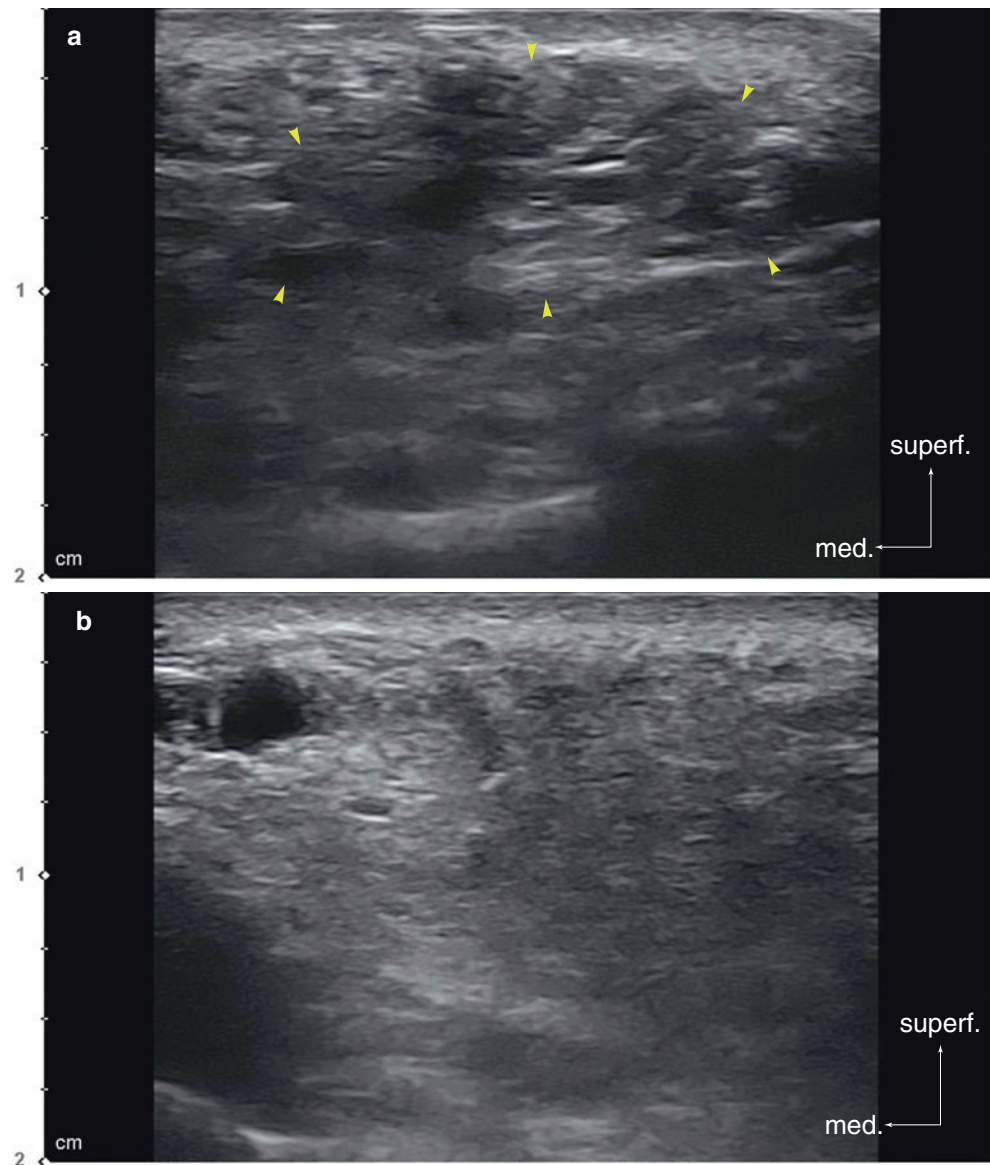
Ultrasonography-guided filler removal on the midface. (a) Before injection, B mode (transverse view, 15 MHz by linear transducer) and (b) immediately after injection: collapsed filler, B mode (transverse view, 15 MHz by linear transducer) (yellow arrowheads: HA filler). (Published with kind permission of © Ji-Soo Kim 2020. All Rights Reserved)
